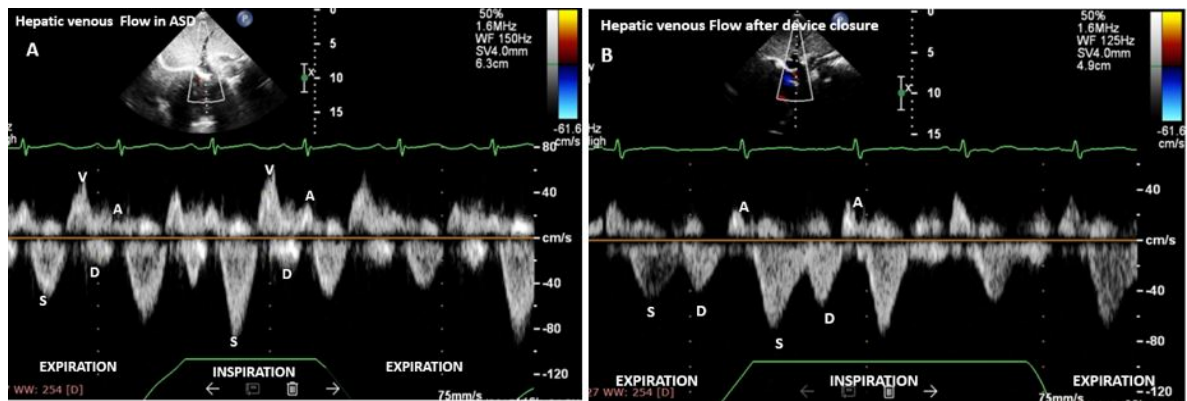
Hepatic venous flow doppler before and after device closure. S; systolic forward flow (S-wave), V; systolic flow reversal (V-wave), D; diastolic forward flow (D-wave), and A; diastolic atrial reversal of flow (A-wave).
